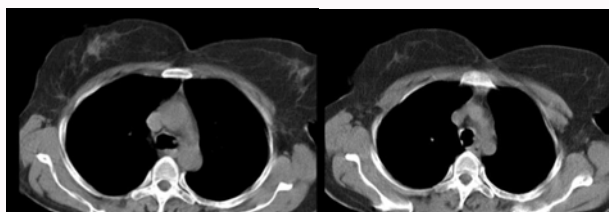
Calcified tracheal nodules in chest CT scan of patient.
